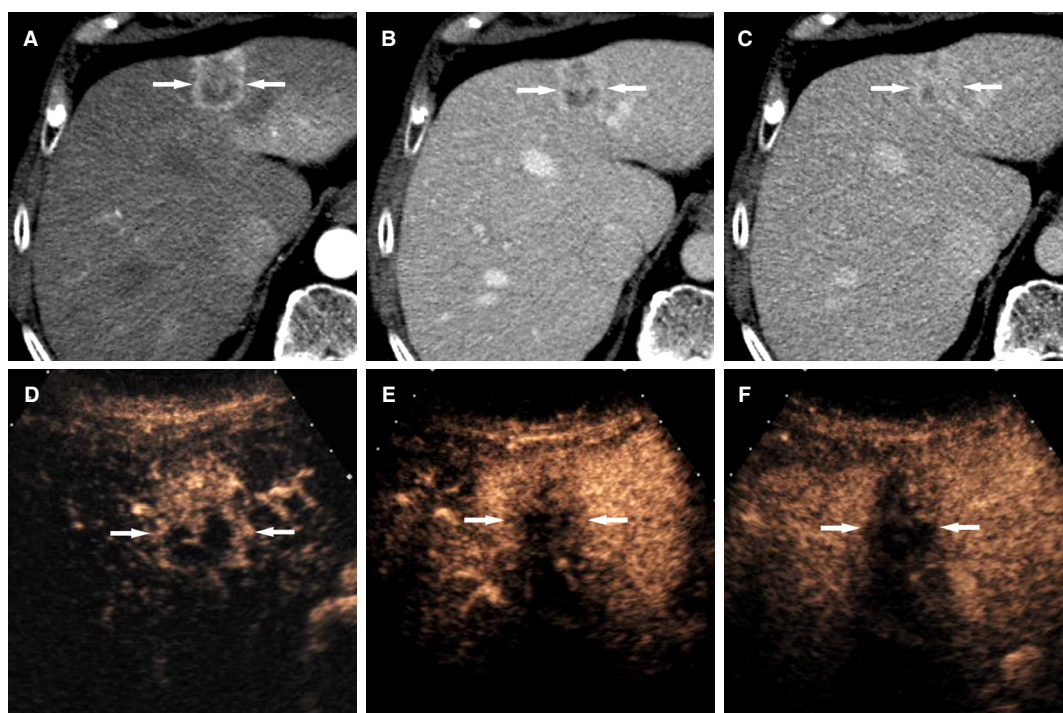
Intrahepatic cholangiocarcinoma in a 78-year-old man with hepatitis-C related liver cirrhosis. A: CT scans in the arterial phase shows a mass with rim arterial-phase hyperenhancement (arrows); CT scans in the portal venous (B), and delayed (C) phases demonstrates gradual enhancement of the mass (arrows); C: there is also heterogeneous hyperenhancement in the delayed phase; D: CEUS in the arterial phase shows irregular rim arterial-phase hyperenhancement in the mass (arrows); E: CEUS at 48 s after contrast injection demonstrates early washout (arrows); F: CEUS at 115 s shows marked washout (arrows). CEUS: contrast enhanced ultrasound
